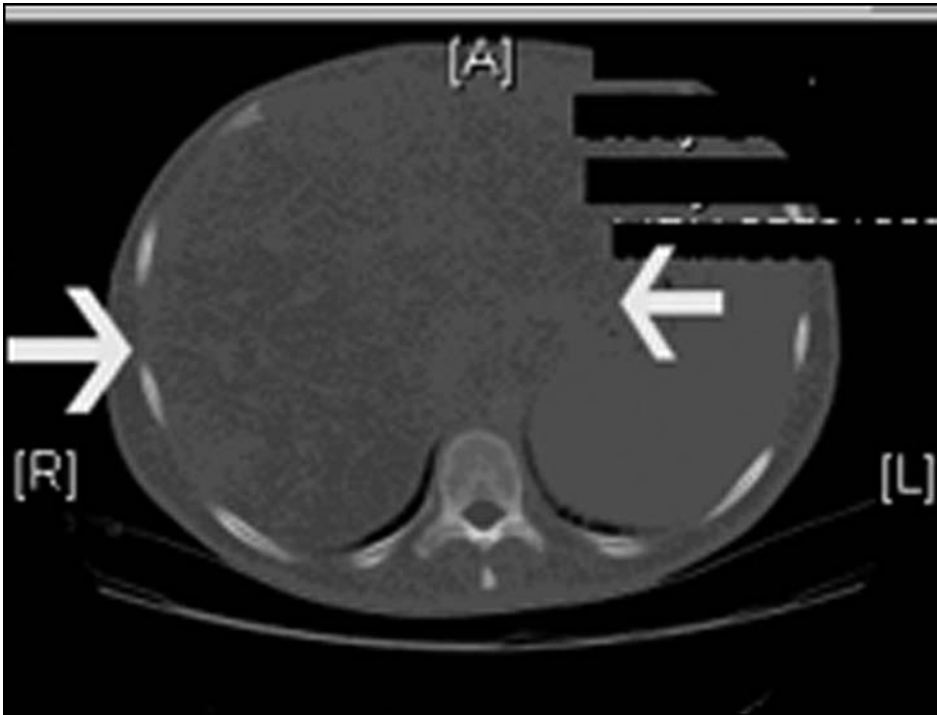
CT of the abdomen of the patient revealed enlarged liver with fatty infiltration (white arrows) and absence of sc and intraabdominal fat.
